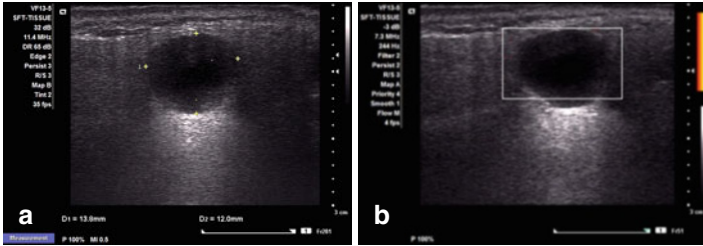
Parotid gland cyst. US shows a round nodule with well-defined margins, anechoic pattern, posterior acoustic enhancement, and no vascularity by Doppler exam
